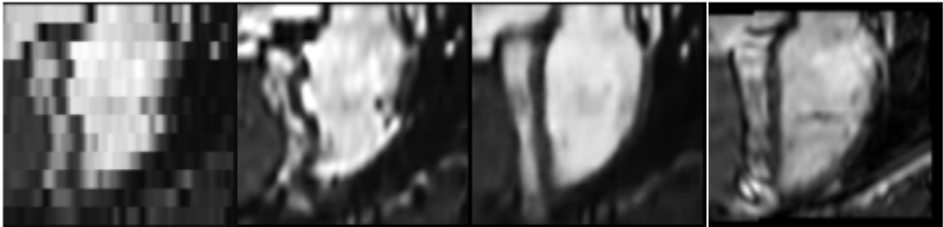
Image super-resolution (SR) results. From left to right, input low resolution MR image, baseline SR approach [34] (no global loss), the proposed anatomically constrained SR model, and the ground-truth high resolution acquisition.
